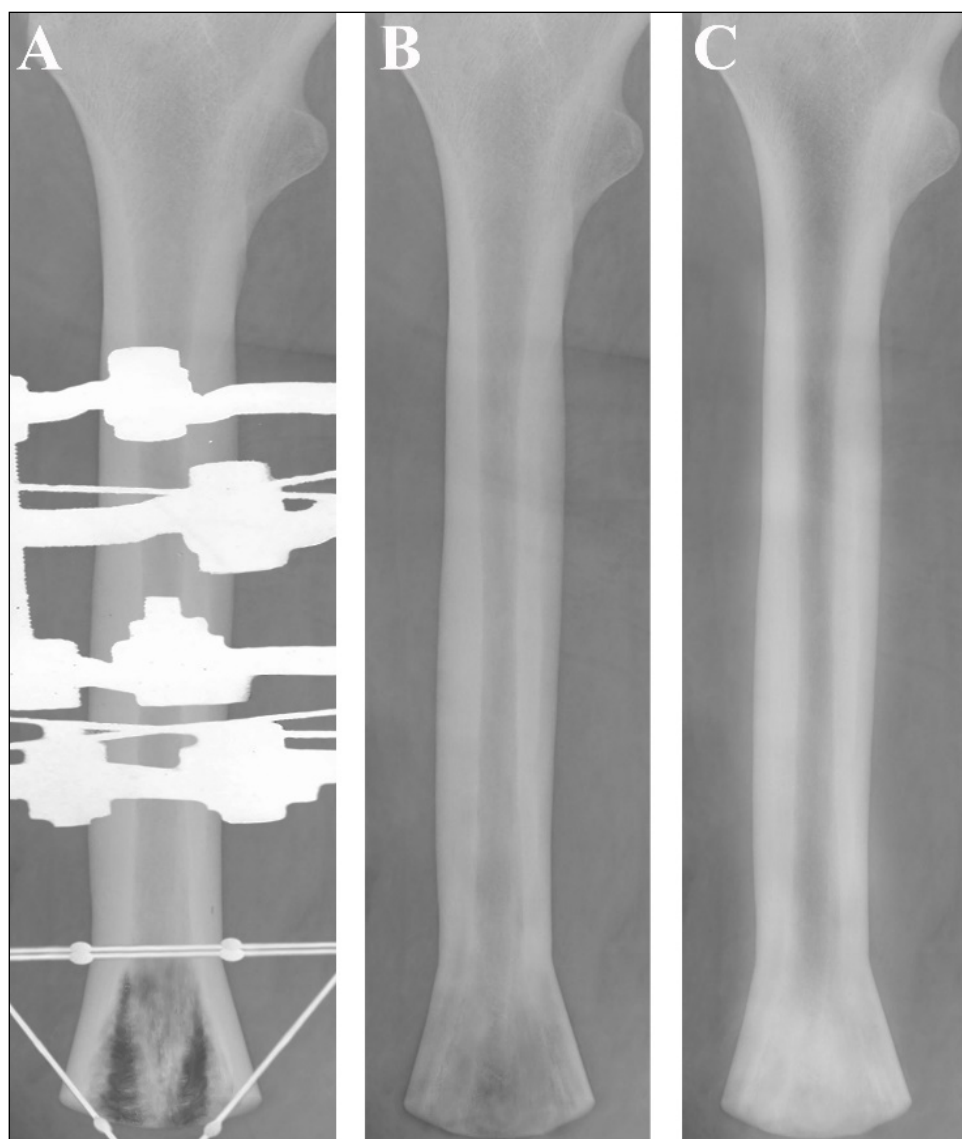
Radiographs of the hip stump: A) during distraction, B) 1 year after surgery, C) 4 years after surgery
